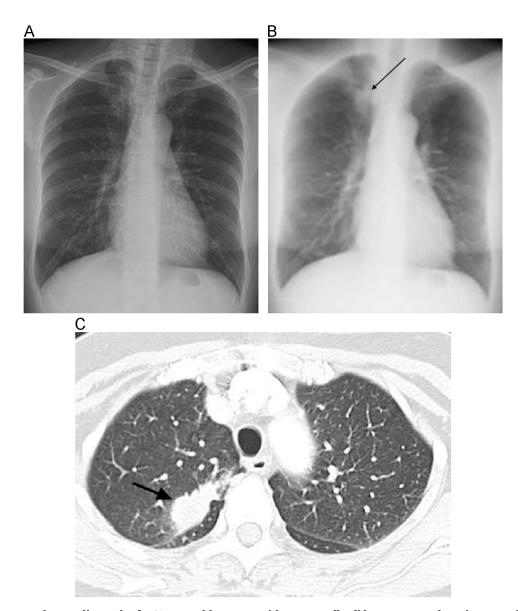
Dual-energy chest radiograph of a 60-year-old woman with non-small cell lung cancer. The primary malignancy in the right upper lobe is suboptimally seen radiographically due to superimposed bone structures (A) but becomes much more evident after bone subtraction (arrow) (B). A CT image with lung window settings (C) confirms the presence of a right upper lobe mass (arrow).
